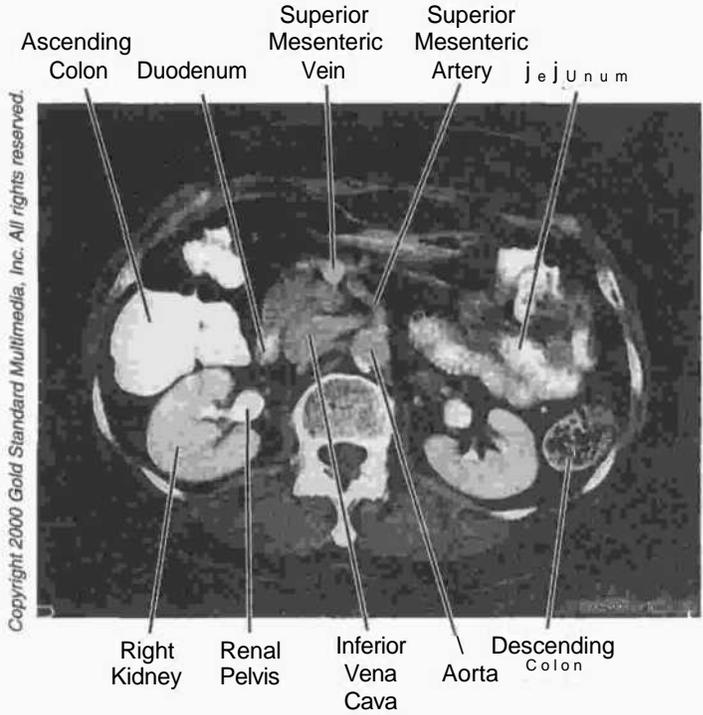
Abdomen: CT, L₂
